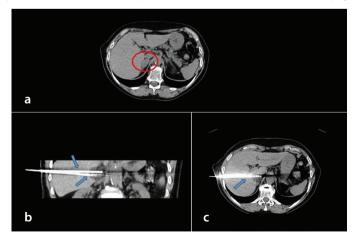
A 68-year-old man with a history of non-small cell lung cancer with solid right adrenal metastasis (red circle in the preoperative computed tomography scan in a). Treatment of the lesion with cryoablation using two Icesphere 1.5 cryoprobes (Visual ICTM, Galil Medical-Boston Scientific, Arden Hills, MN, USA) via transhepatic access (blue arrows in the intraoperative reformatted coronal scan image in b and in the axial plane in c).
